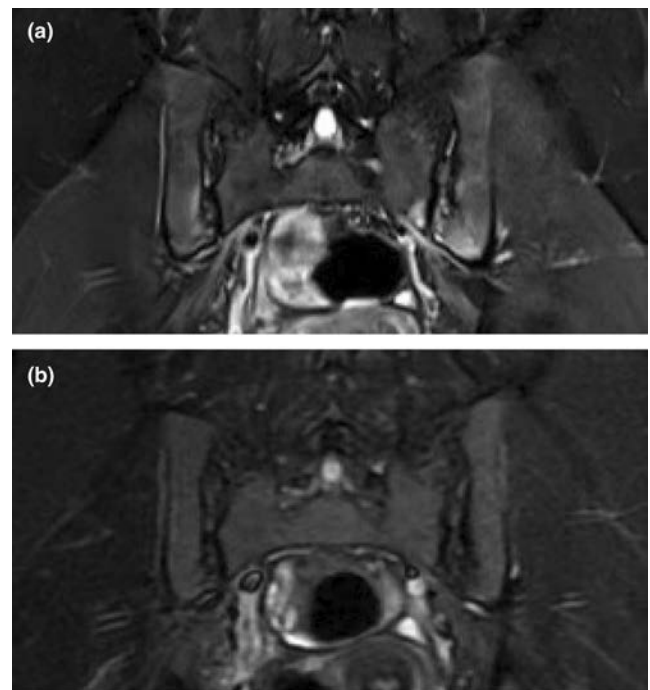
(a, b) MRI of the sacroiliac joint. Prior to versus after 6-month tofacitinib treatment respectively.
